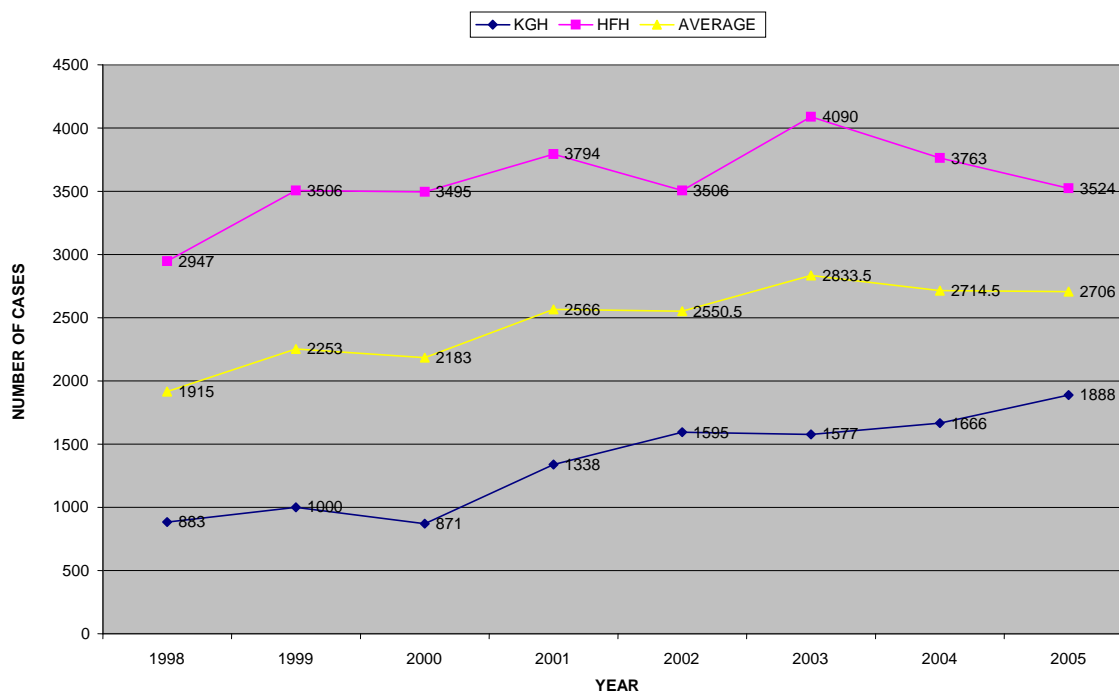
TREND OF UTILISATION OF X-RAY (KGH AND HFH)
